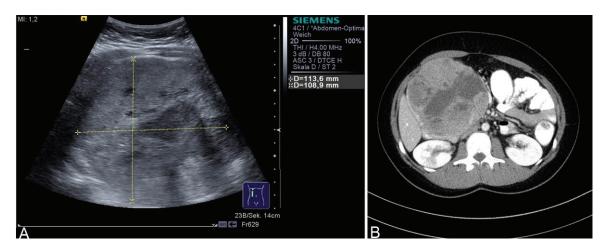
A. Ultrasonography of abdomen showing a circumscribed encapsulated tumor of the upper abdomen. B. Computed tomography of abdomen demonstrating a well-encapsulated, heterogenous mass with solid and cystic lesions arising from the head of pancreas.
